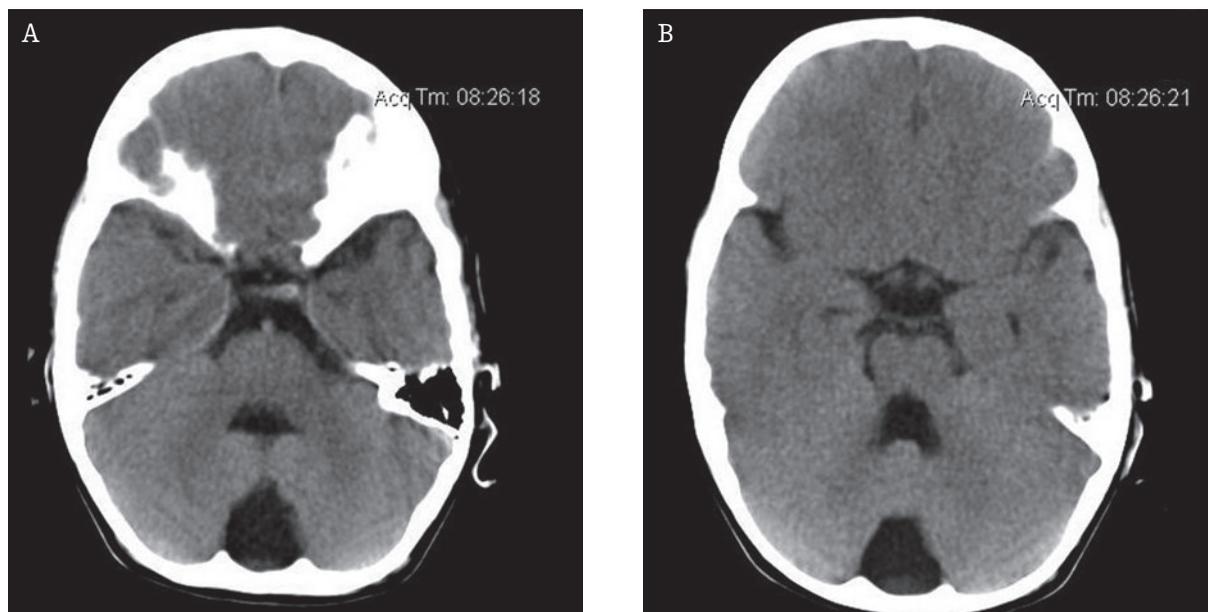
Blake's Pouch Cyst (BPC). On CT axial scans (A, B) show cystic fluid space localized posteriorly to the normal vermis.
